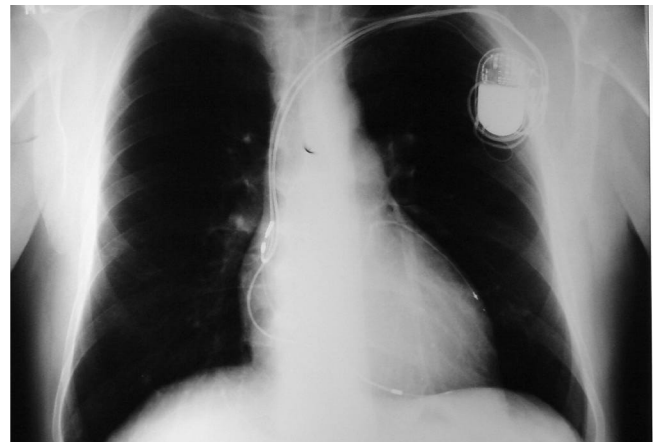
X-ray pre- (panel a) and post-implantation (panel b) of a biventricular pacemaker system (male patient, aged 48).
